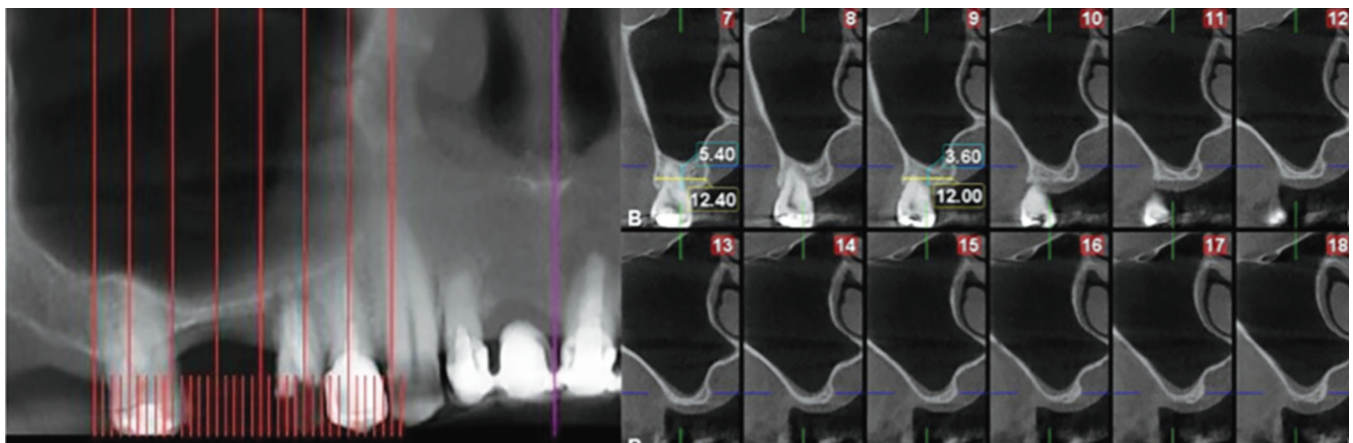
Cone beam computed tomography radiographs demonstrating minimal crestal bone in the posterior maxilla
